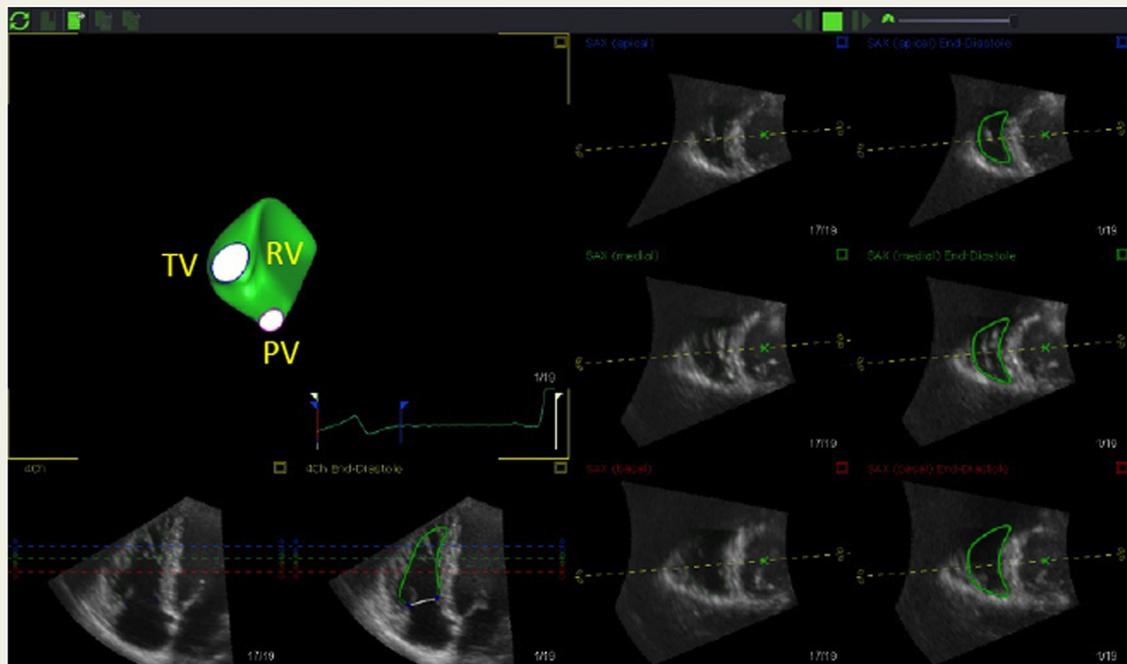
Measurement of RV volumes and ejection fraction using 3D echocardiography. End-diastolic and end-systolic volumes are determined after the endocardial borders are identified from the 3D dataset and used to calculate the right ventricular ejection fraction. The effect of the convex RV surface of the interventricular septum on the shape of the left ventricular cavity can be seen on modelled RV cavity shape.
